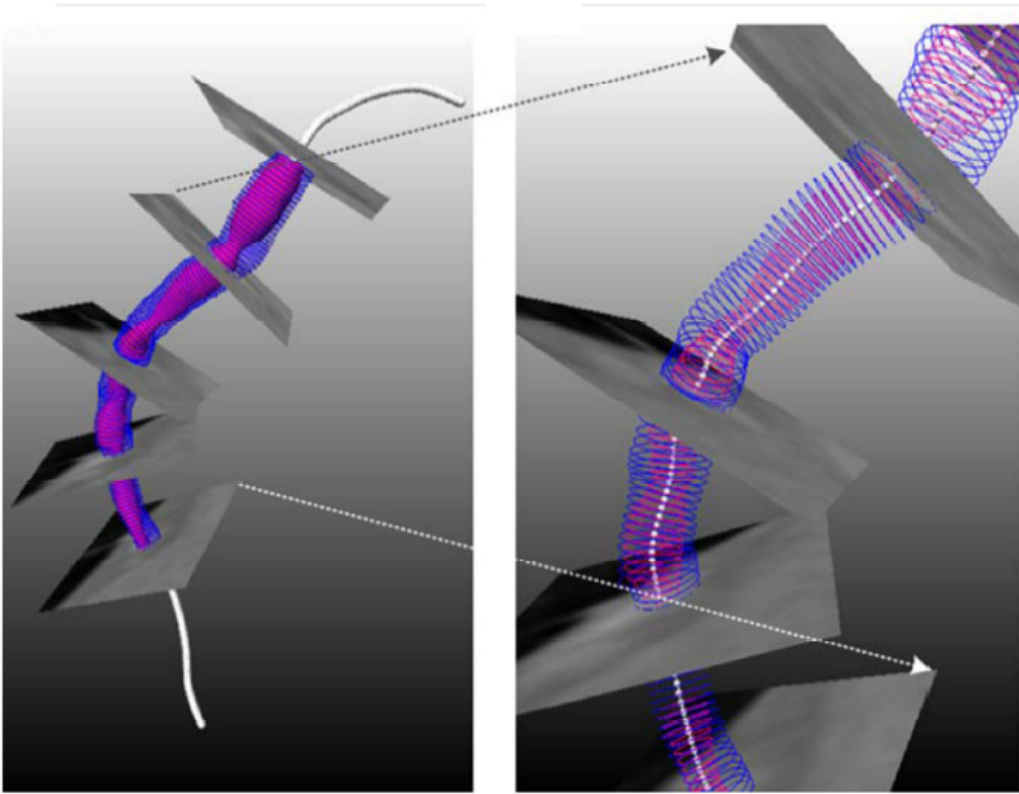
The IVUS 2D images are placed on the CTA derived centreline at correct locations, generating the coronary artery geometry. Pink curves represent the internal lumen, blue ones the exterior wall. On the right, a magnification of the 3D contours. Reprinted with permission from Van der Giessen et al. [204].*
